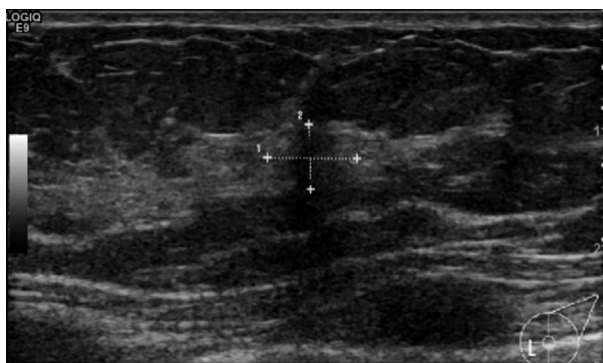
Targeted ultrasound left breast. A 7 mm irregularly shaped, ill-defined hypoechoic mass is present in the lower inner quadrant at the eight-thirty o'clock position. This corresponds to the lesion shown on the mammogram and is likely to represent the lesion shown on the earlier MRI examinations. Ultrasound guided core biopsy: grade 2 infiltrating ductal carcinoma. Patient chose to undergo bilateral mastectomies with immediate reconstruction.
